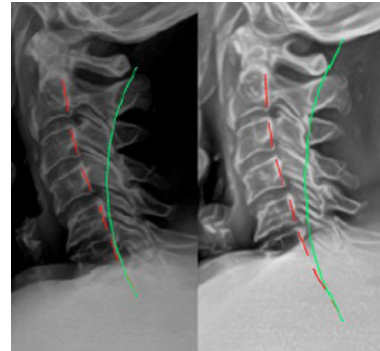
Lateral cervical radiographs. Left: Initial (Oct. 16, 2018) showing forward head translation, hypolordosis, and a reduced atlas plane line as well as overt osteoarthritis from C2–C7. Right: Follow-up (May 3, 2018) showing improvement in alignment.
